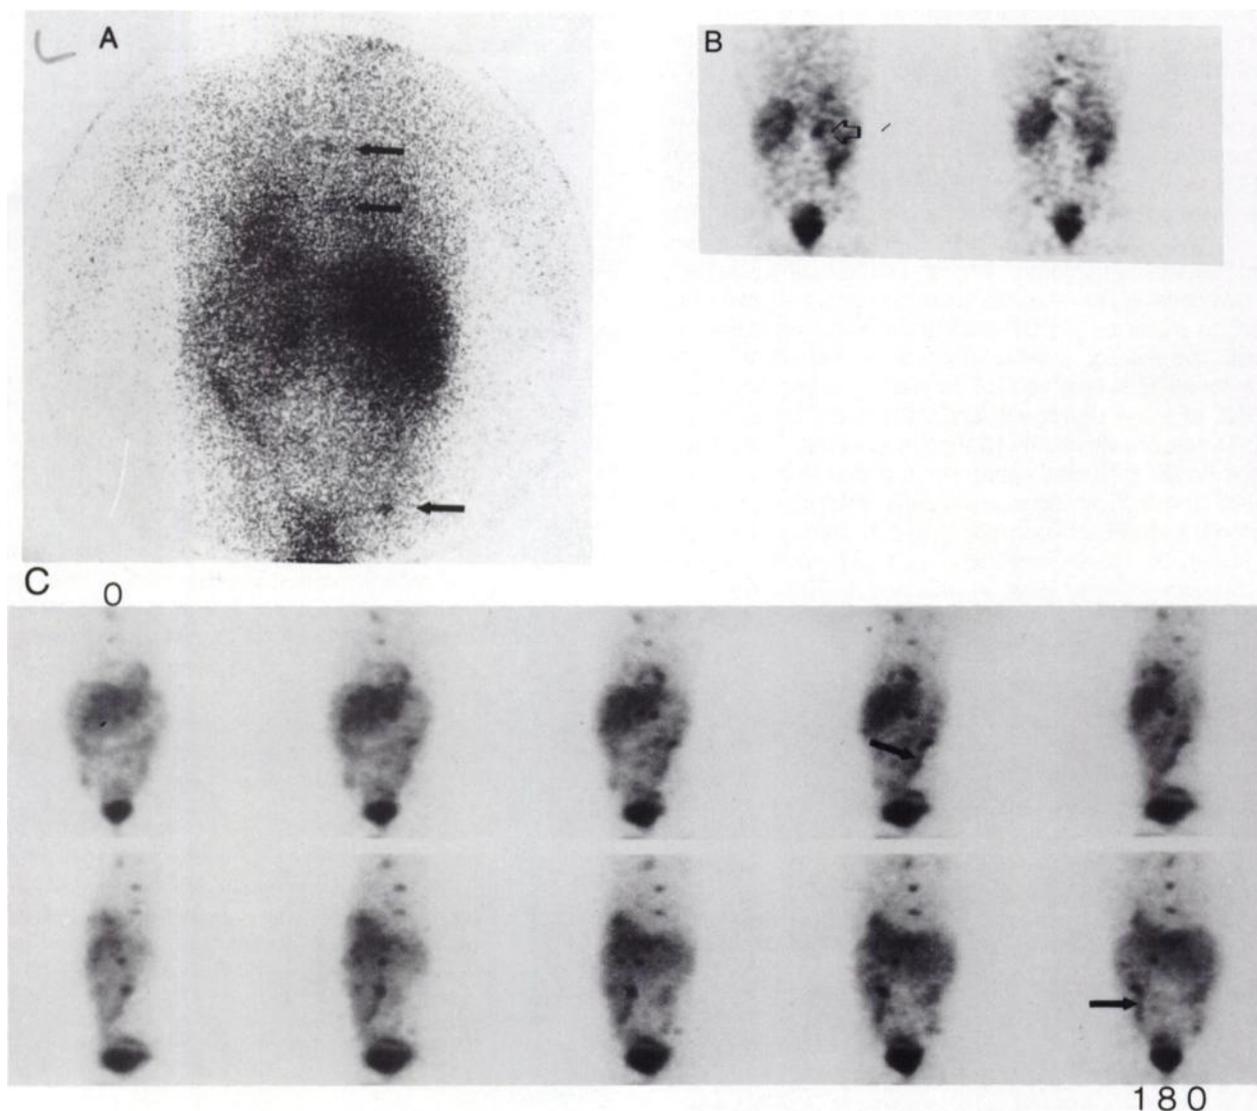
This 8-yr-old boy was examined 2 yr after bone marrow transplant (BMT) for advanced neuroblastoma. Since BMT, two foci of uptake in the spine and one in the right ilium (closed arrows) have consistently been unchanged on ¹²³I-MIBG scintigraphy during a period when the patient received no additional therapy. These foci of uptake are visible on planar imaging (A), but they are better localized and more clearly seen on coronal SPECT (B). A left adrenal gland is also identified (open arrow). On the basis of prolonged clinical observation, it is believed that the foci of uptake in the spine and pelvis had probably matured to ganglioneuromas, and biopsy was deferred. Volume-rendered images (C) from 0° (anterior) to 180° at 20° intervals. Activity in the colon is identified. As the projection is rotated, the edge of the veil of minimal, diffuse small-bowel activity (closed arrows) rotates, allowing the reader to inspect the retroperitoneum.
